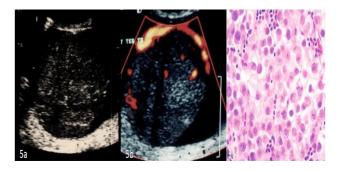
Seminoma (a) Longitudinal and transverse scans though Rt. Testis depict grossly enlarged testis with relatively homogenous and hypo echoic parenchyma replacing the entire testis. A case of seminoma testis; (b) On color Doppler and PD the mass lesion was hypervascular (grade III) with large vessels in disorganized manner. (c) HPE shows clear tumor cells and lymphocytes- suggested seminoma.
